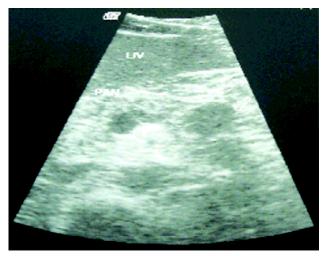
Ultrasound image showing a hypochoic lesion at the junction of the body and tail of the pancress.
